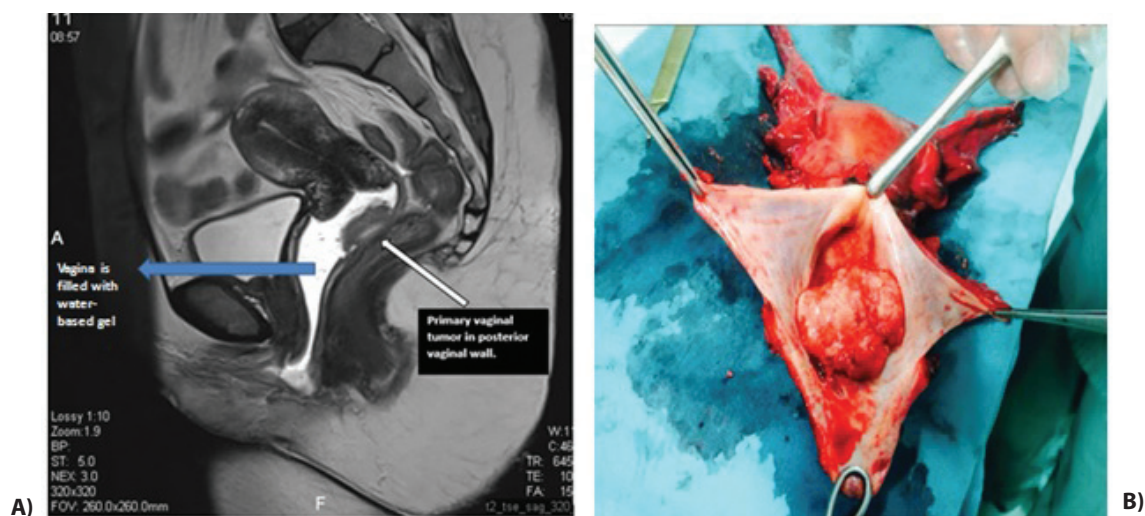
• A) Magnetic resonance imaging shows tumor limited to vaginal epithelium. B) Radical resection with enbloc vaginectomy.
